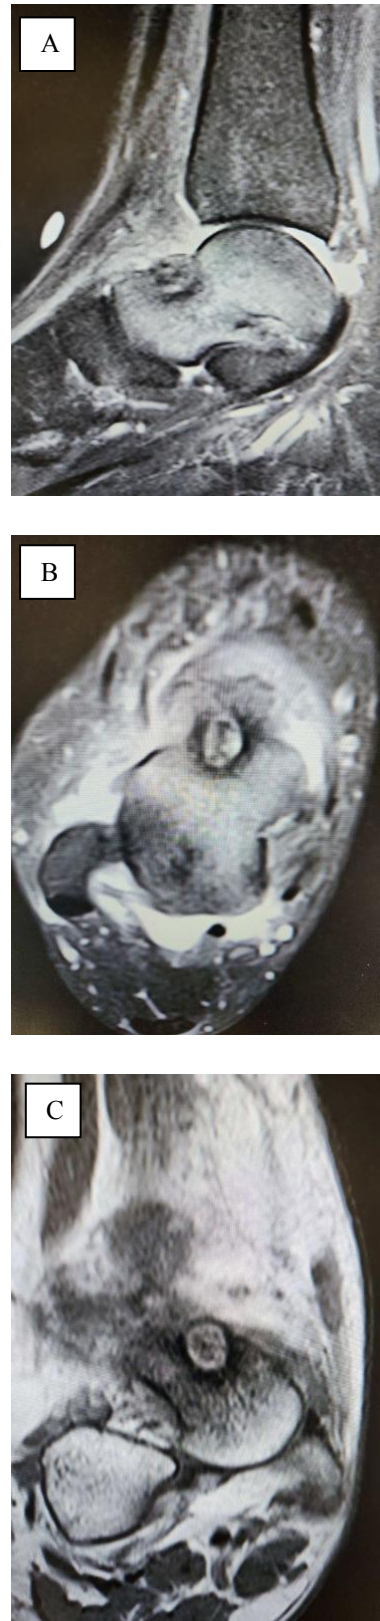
2B,2C. MRI of the right ankle- sagittal, coronal, and axial; respectively.
